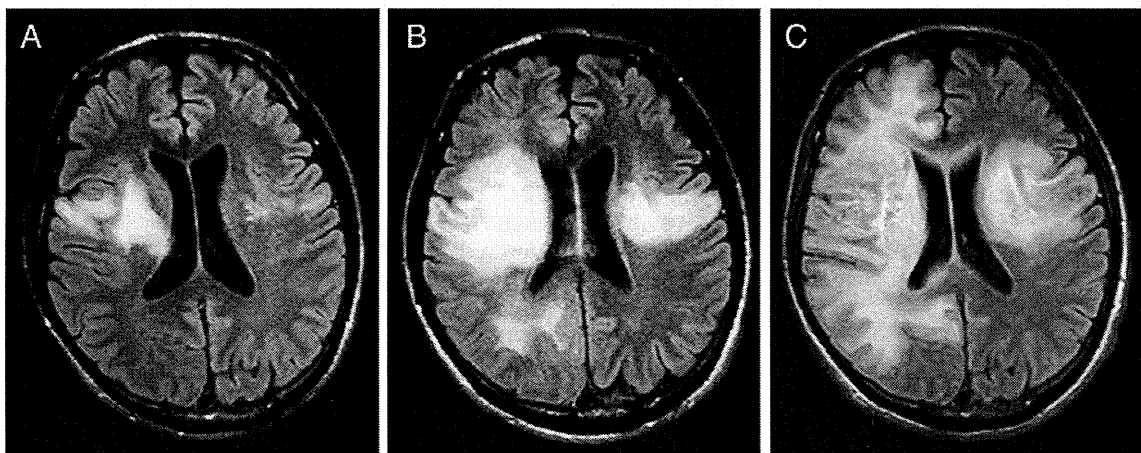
A. Fluid-attenuated inversion recovery (FLAIR) sequence of brain MRI before initiation of mefloquine demonstrated high intensity areas in the white matter of the bilateral frontal lobes. B, C. FLAIR sequence of brain MRI 38 days (B) and about 3 months (C) after the initiation of mefloquine showed lesion expansion.
